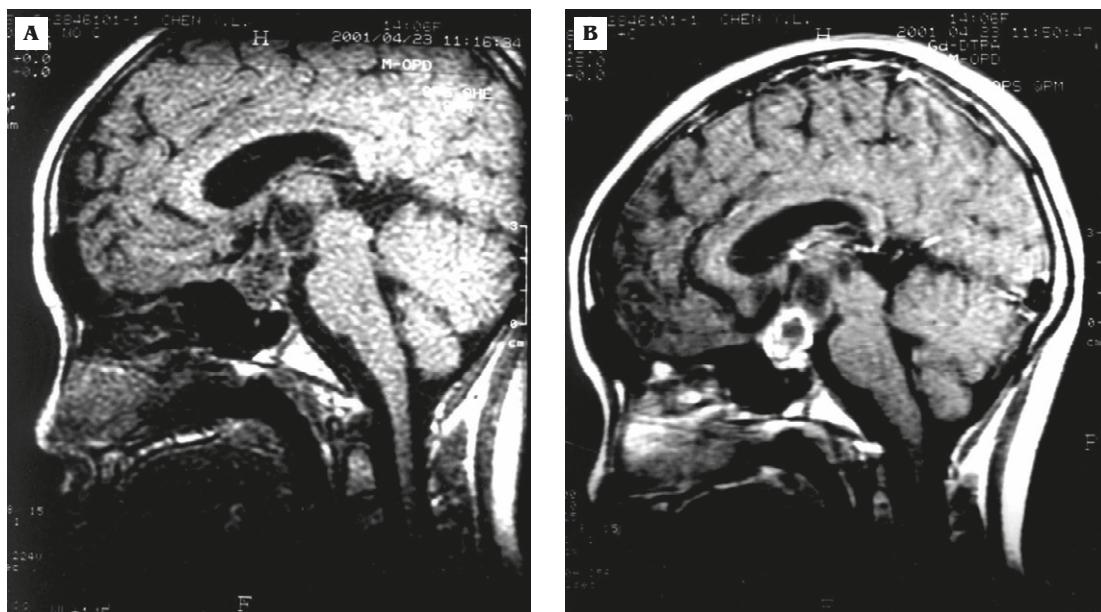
(A) T1-weighted sagittal image (TR 400/TE 25) without gadolinium shows a space-occupying suprasellar lesion with mixed solid and cystic components. The cystic portion has low signal intensity. (B) T1-weighted sagittal image with gadolinium reveals enhancement of the solid component of the tumor.
